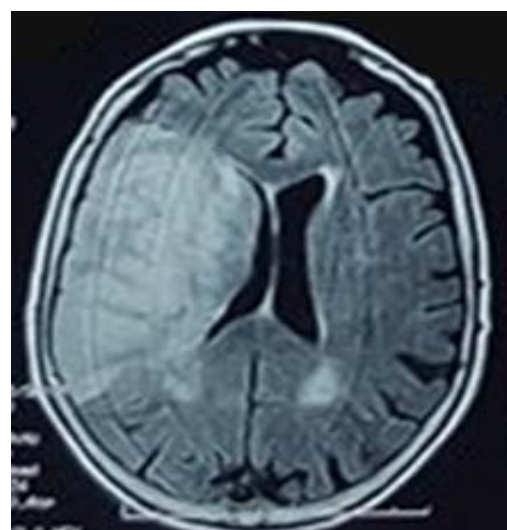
Cerebral MRI performed 24 Hours later showing extended right sylvian AVCI
